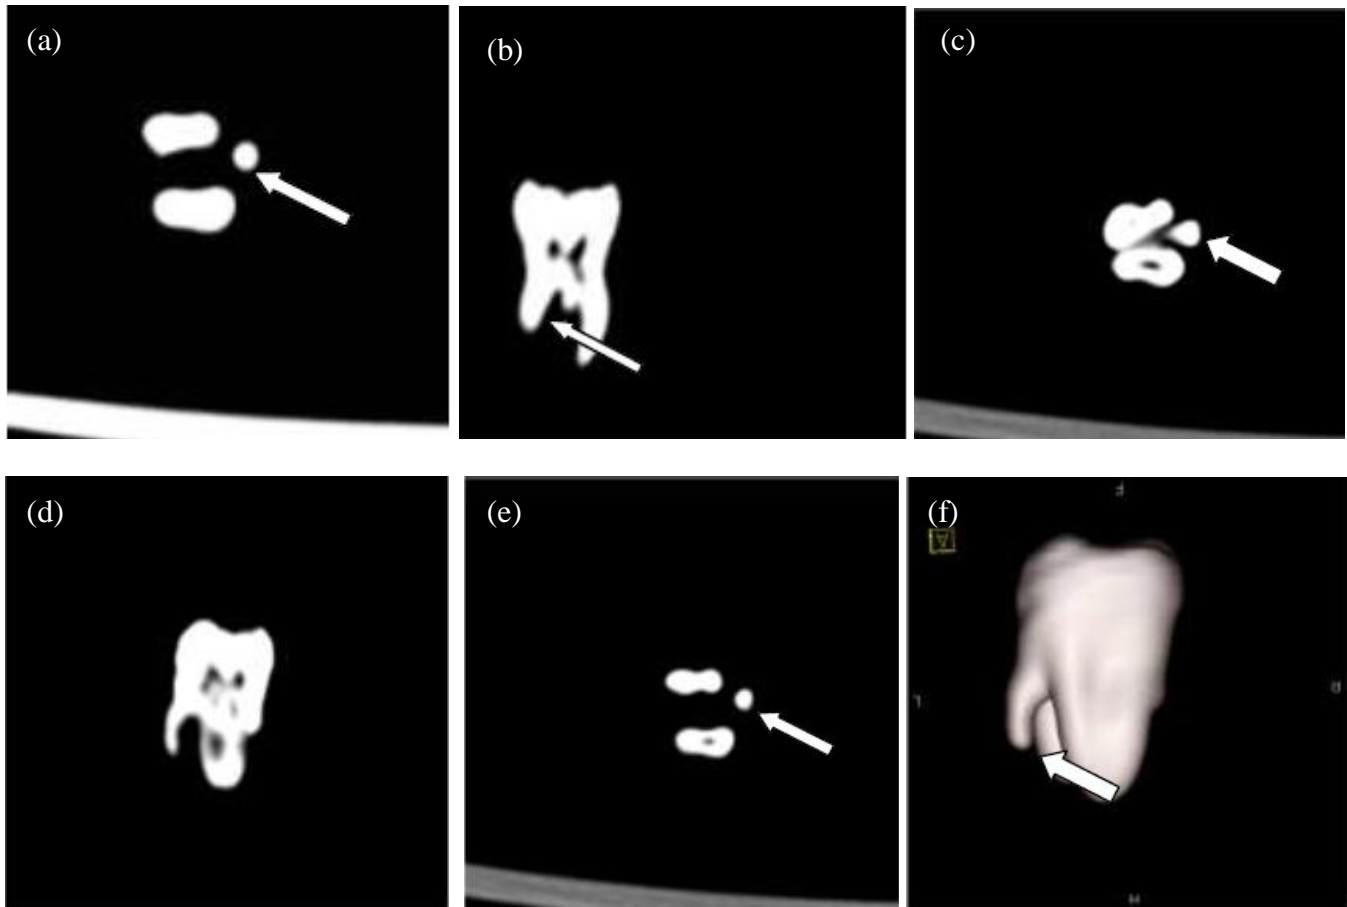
(a-f): Spiral CT's showing RE.
